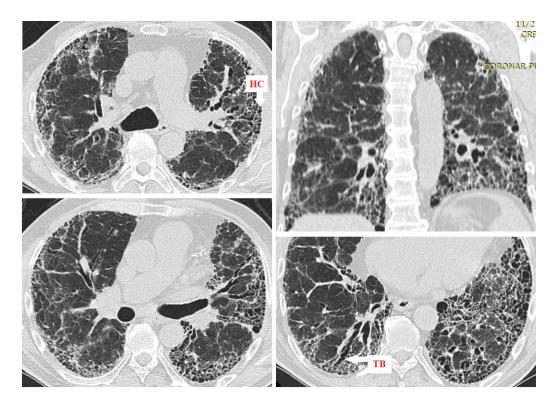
HRCT images demonstrating a UIP pattern Honeycombing (HC) with peripheral tractionbronchiectasis (BT)
